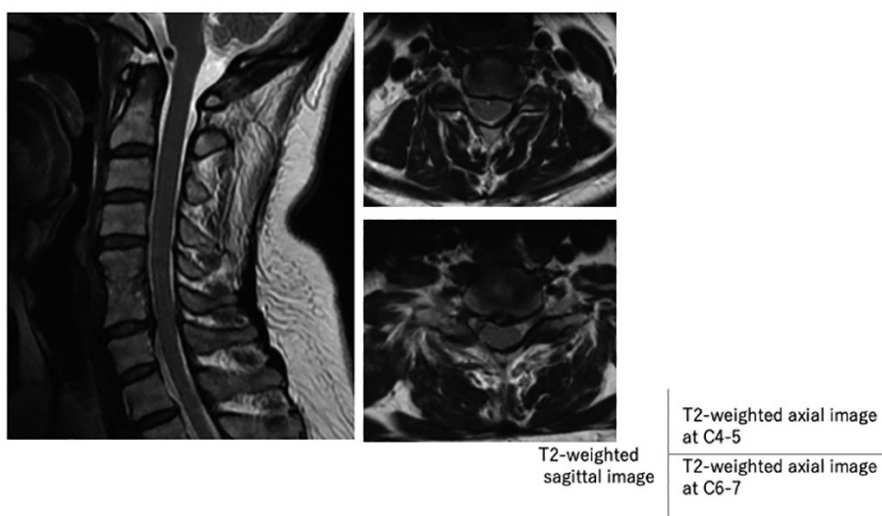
Follow-up MRI studies at 4 years after initial ACDF without plate fixation. The T2-weighted images showed an adequate decompression and solid fusion at C5-6 with only a mild asymptomatic ASD at C6-7.
